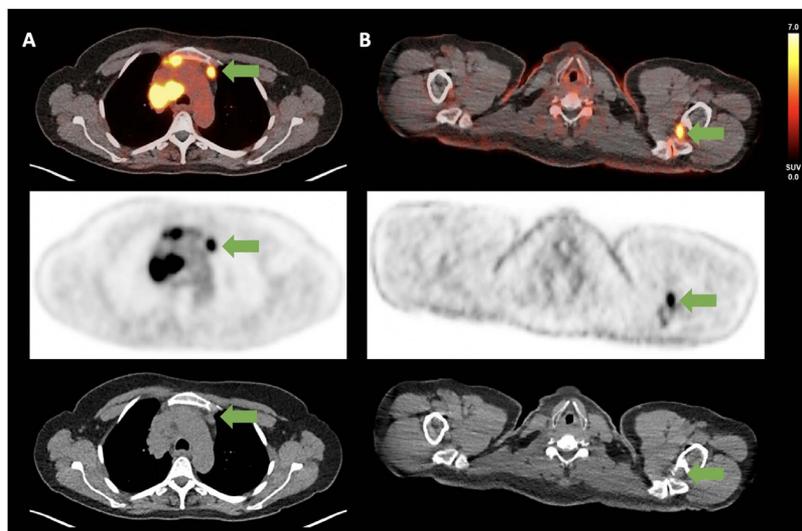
Examples of FAP-RADS lesions. (A) The green arrow points to an enlarged mediastinal lymph node with intense FAPI uptake (SUVmax 9.33) in a lung cancer patient (FAP-RADS 5). (B) The green arrow points to an intra-articular FAPI uptake (SUVmax 10.02), which is attributed to degenerative changes (FAP-RADS 1).
